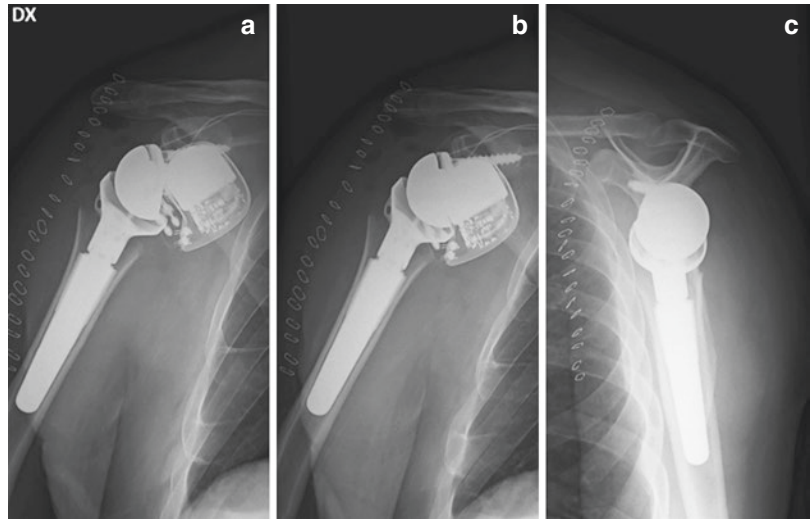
Postoperative radiographic control performed the day after surgery at another institution, showing the implant of the reverse total shoulder arthroplasty. (a) Anteroposterior shoulder internal rotation view. (b) Anteroposterior shoulder external rotation view. (c) Shoulder outlet view
